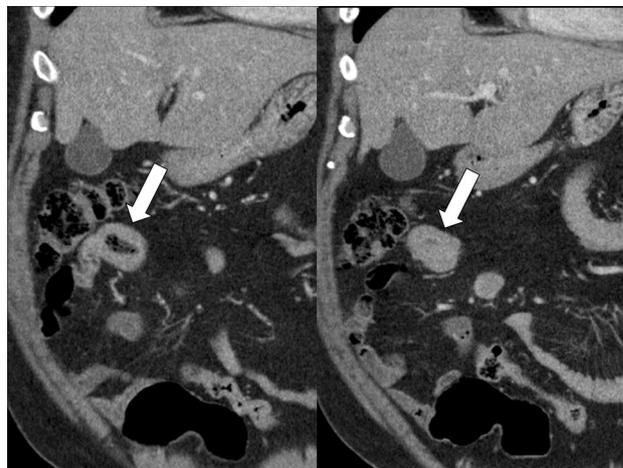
A 47-year-old man with abdominal discomfort. Coronal CT images show circumferential wall thickening with iso-to-low attenuation in the small bowel. Because no bowel obstruction was observed, our initial diagnosis was lymphoma rather than adenocarcinoma. However, this mass was proven to be adenocarcinoma after surgical resection
